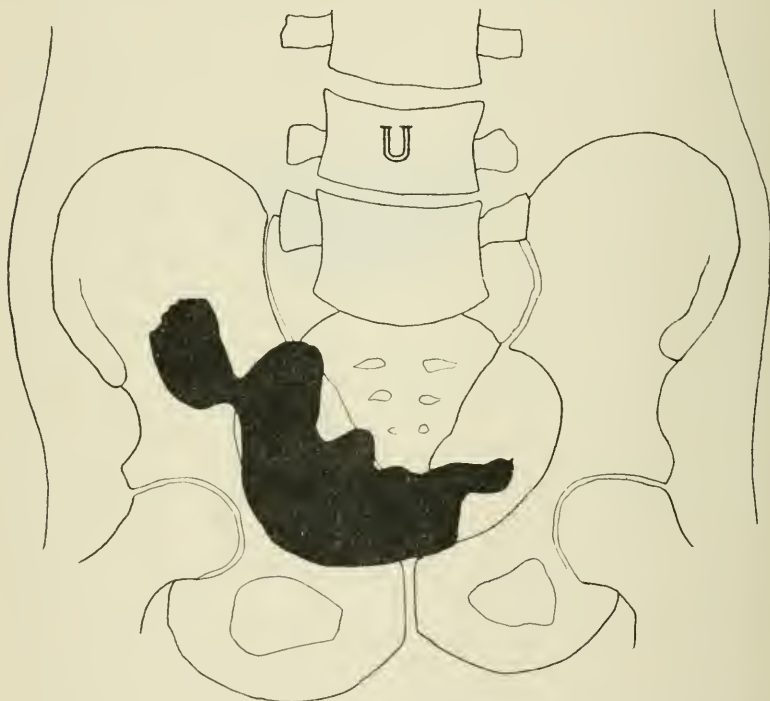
Reduced tracing from X-ray Plate taken six hours after Bi-meal.
